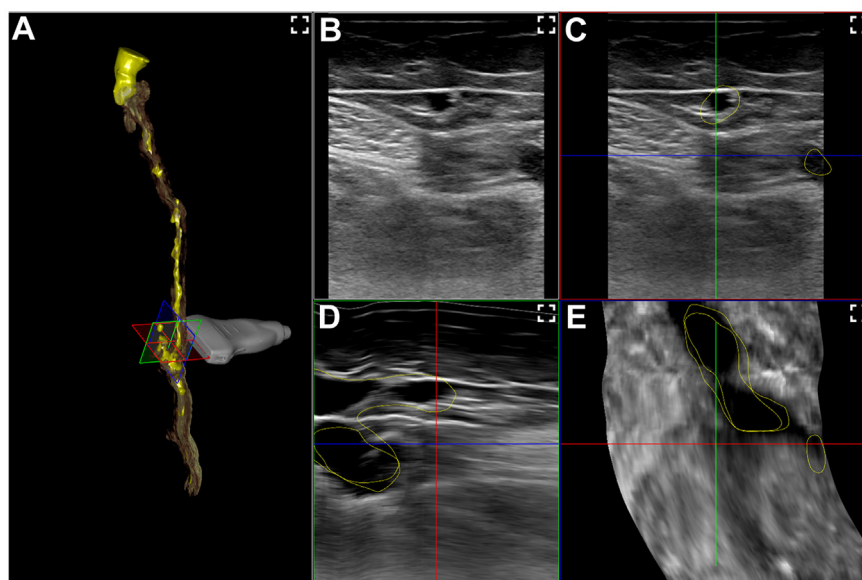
Multiplanar reconstructions and a volumetric image are then computed from the ultrasound frames using these positional data. (A) Three-dimensional (3D) reconstruction. (B) Original two-dimensional (2D) image. (C) Multiplanar reconstruction of the transverse plane. (D) Multiplanar reconstruction of the sagittal plane. (E) Multiplanar reconstruction of the frontal plane.
